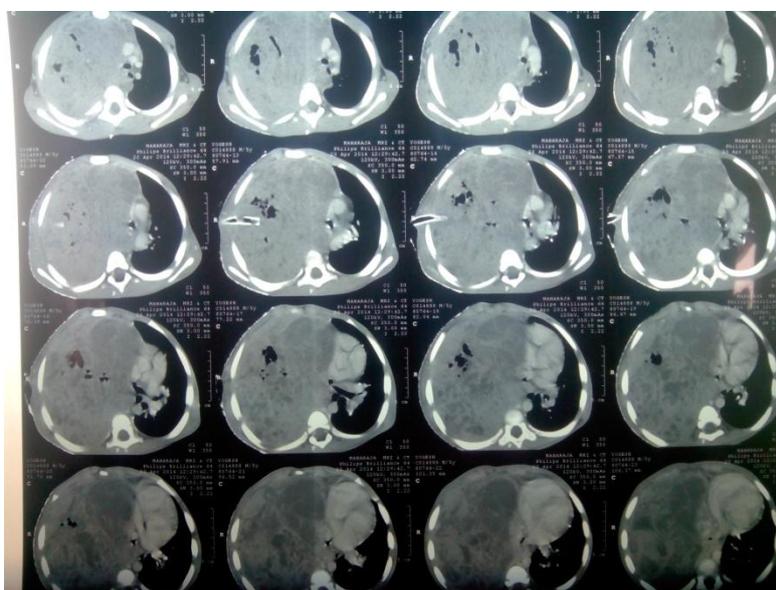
CT Thorax showing posterior mediastinal mass
